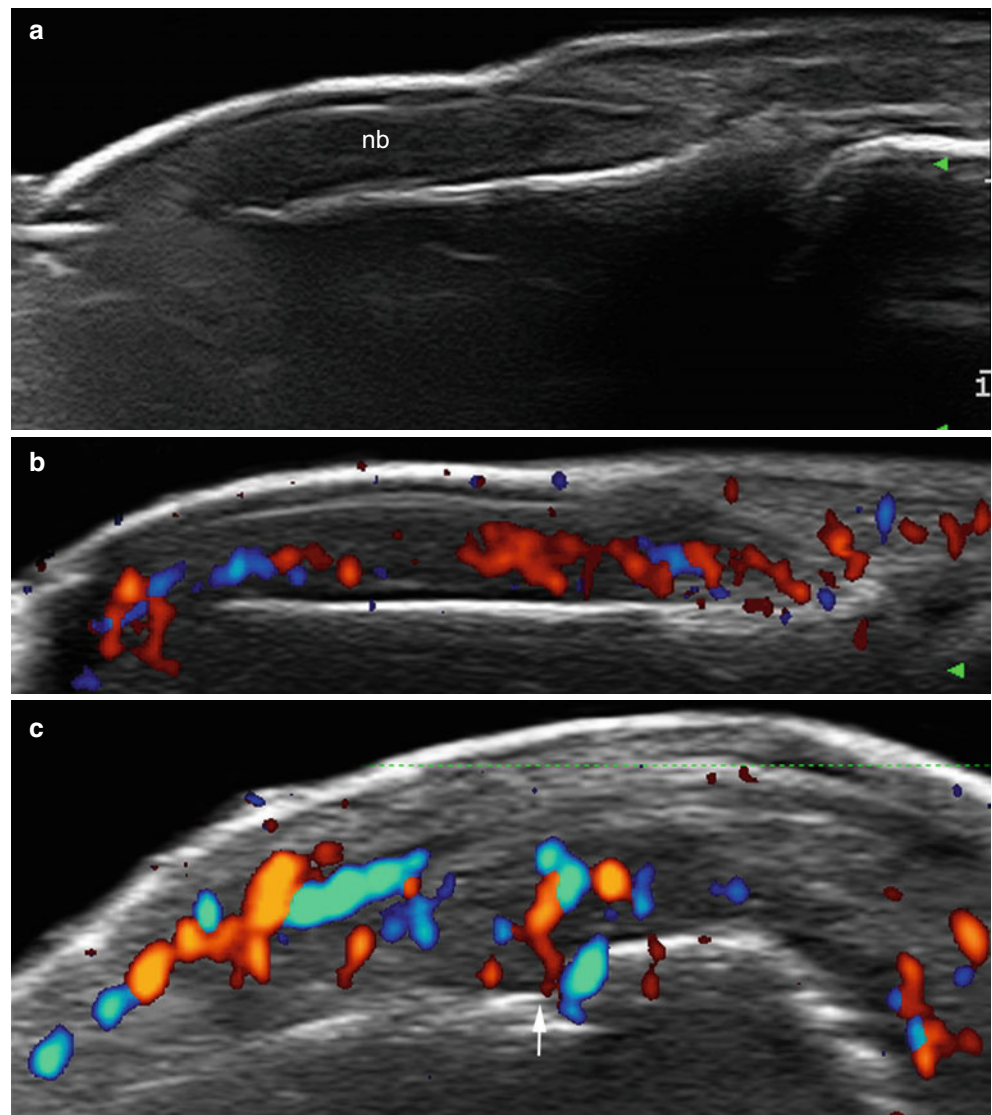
(a–c) Rheumatoid arthritis. (a) Grey scale ultrasound image (longitudinal view, right index finger) shows diffuse thickening and hypoechoogenicity of the nail bed. Loss of definition of the ventral plate, thickening of the dorsal plate, and a slight upward displacement of the nail plates (dorsal and ventral) are also detected. (b) Color Doppler ultrasound image (longitudinal view, right index finger) shows a mild increase of vascularity, mainly in the proximal region of the nail bed. (c) Color Doppler ultrasound image (longitudinal view, radial aspect of the base of the middle phalanx in the right index finger) shows a bony erosion (*arrow*) and hypervascularity of the surrounding soft tissues
